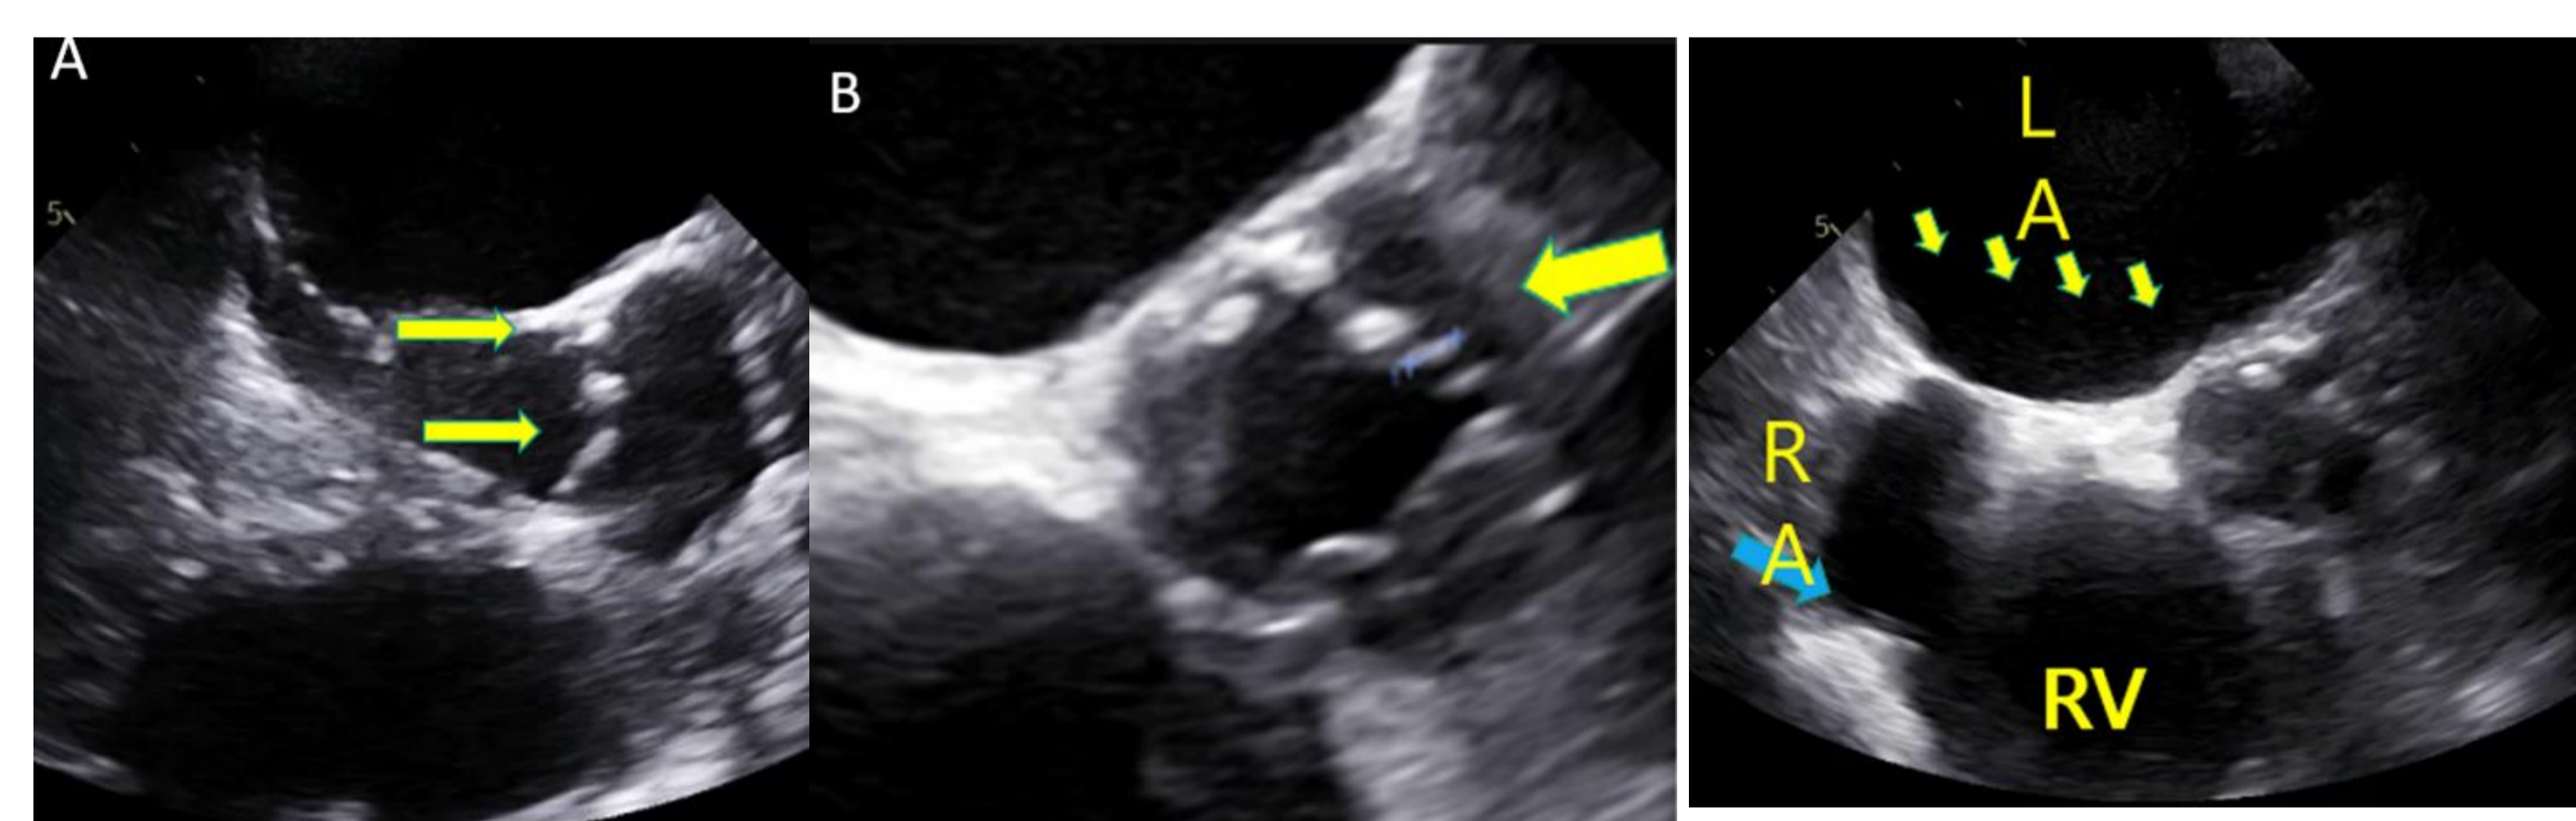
Transesophageal echocardiogram A. Long axis view showing vegetations on the non coronary cusp and right coronary cusp measuring 3.42mm and 3.42mm respectively. B. Short axis view showing vegetation on the left coronary cusp
